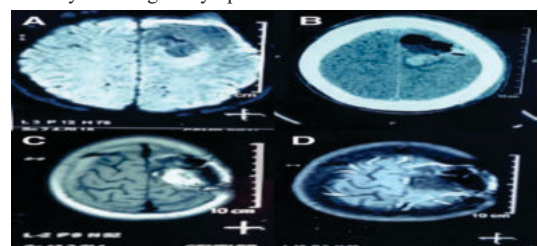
A) CEMRI of brain DW T2 FLAIR image showing heterogeneous area of abnormal signal intensity in the left posterior frontal region with associated edema and left parasagittal lesion measuring 3.1×3.7×3.1 cm. B) Post-operative CECT of brain showing heterogeneous non-enhancing area of abnormal hyper attenuation with internal cystic areas and air locules in left fronto-parietal lobe and mild associated edema suggestive of resection cavity. C&D) CEMRI of Brain done (T2/FLAIR) revealed hyperintensities noted in the left superior frontal cortex and subcortical white matter with no associated diffusion restriction or post contrast enhancement.
